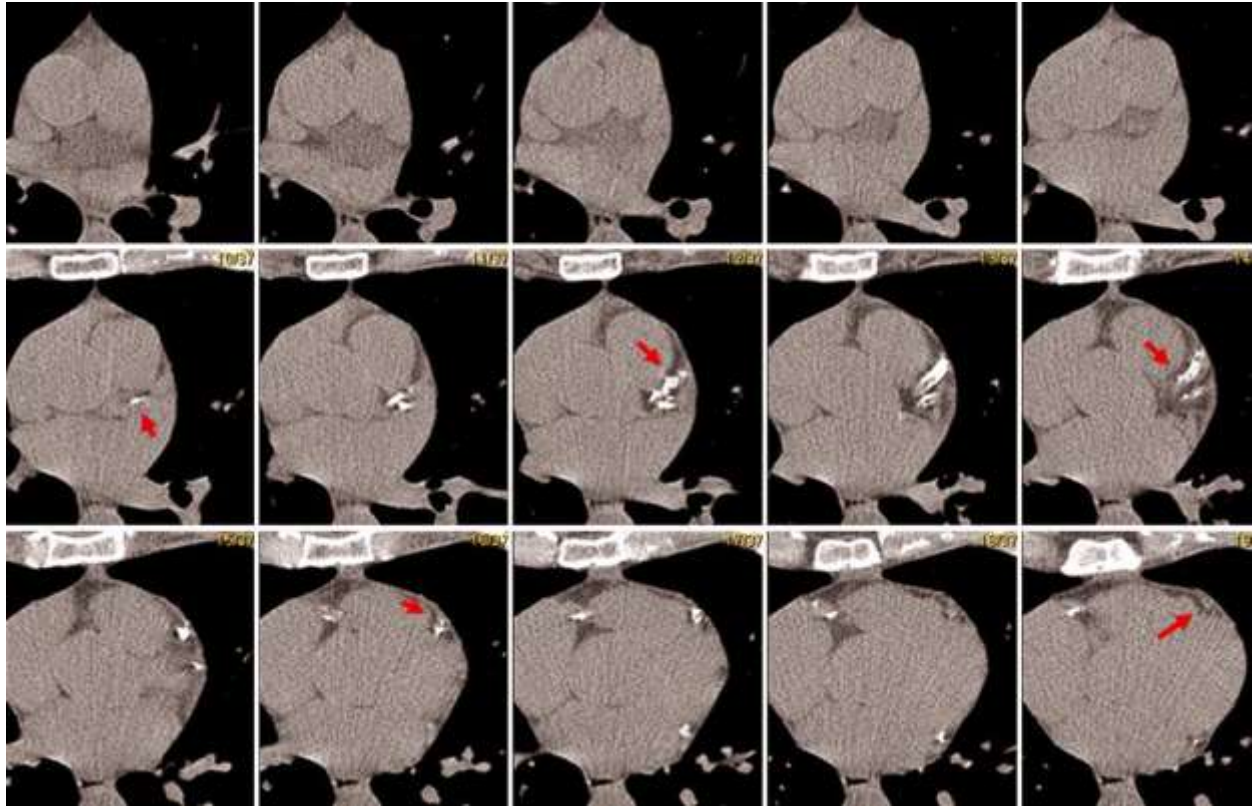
Sequential 3 mm slices from a non-contrast CT scan study (calcium scan). This study depicts the course and calcifications of the left anterior descending (LAD) artery. The white calcifications are easily seen (red arrows) and quantitated by the computer to derive a calcium score, volume or mass with high inter-reader reproducibility. (Budoff et.al (2010)).
